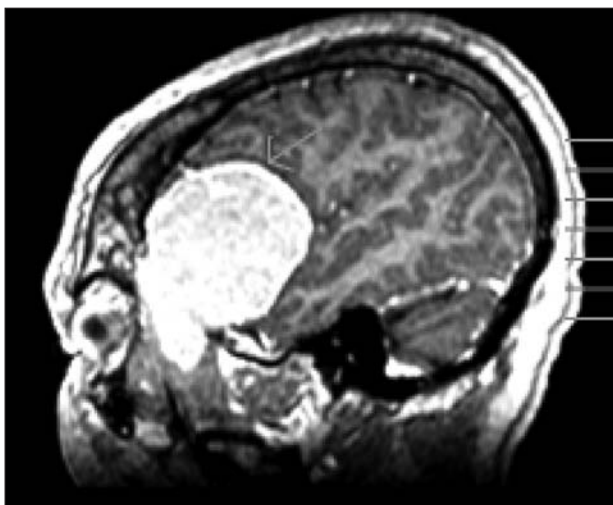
A T1 sagittal MR image showing intracranial mass (arrow) causing a mass effect on the brain.
